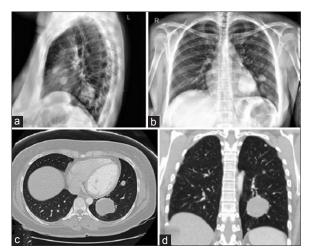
Imaging of multiple pulmonary nodules in the left lower and upper lobe seen on lateral (a) and anterior posterior (b), X-ray views, as well as on sagittal (c) and axial (d) CT imaging
